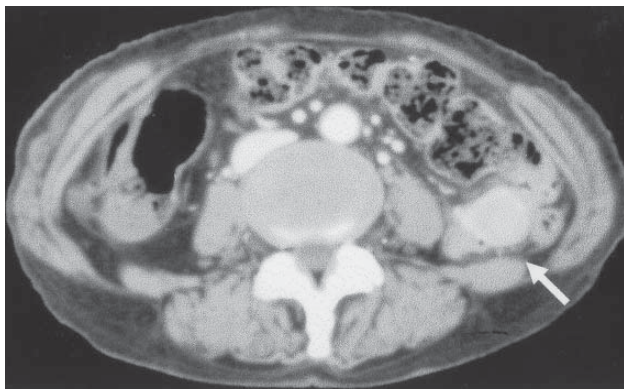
The contrast-enhanced computed tomography revealed a lower abdominal tumor arising from the small intestine (arrow).
